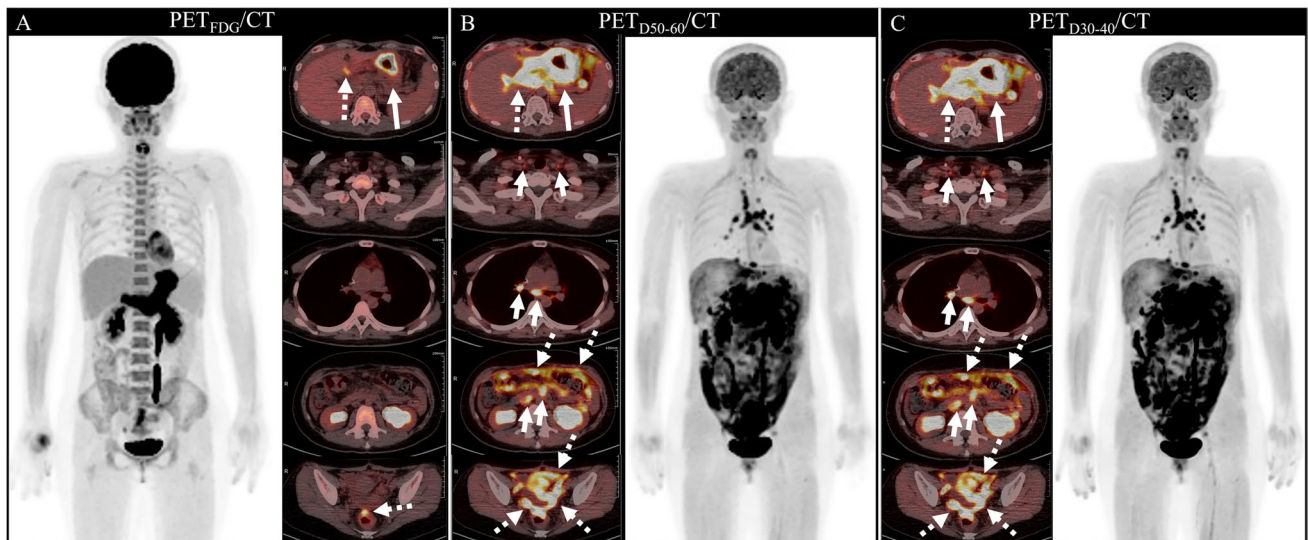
A 32-year-old woman with confirmed gastric adenocarcinoma. A Images from [¹⁸F]FDG PET/CT show obvious tracer uptake in the stomach (long arrow), accompanied by suspected peritoneal metastases (dashed arrows) in the area of hepatic hila and in the pelvic floor in front of rectum. B Images from dual-tracer PET_{D50-60}/CT demonstrate higher tracer uptake of greater extent in both primary
